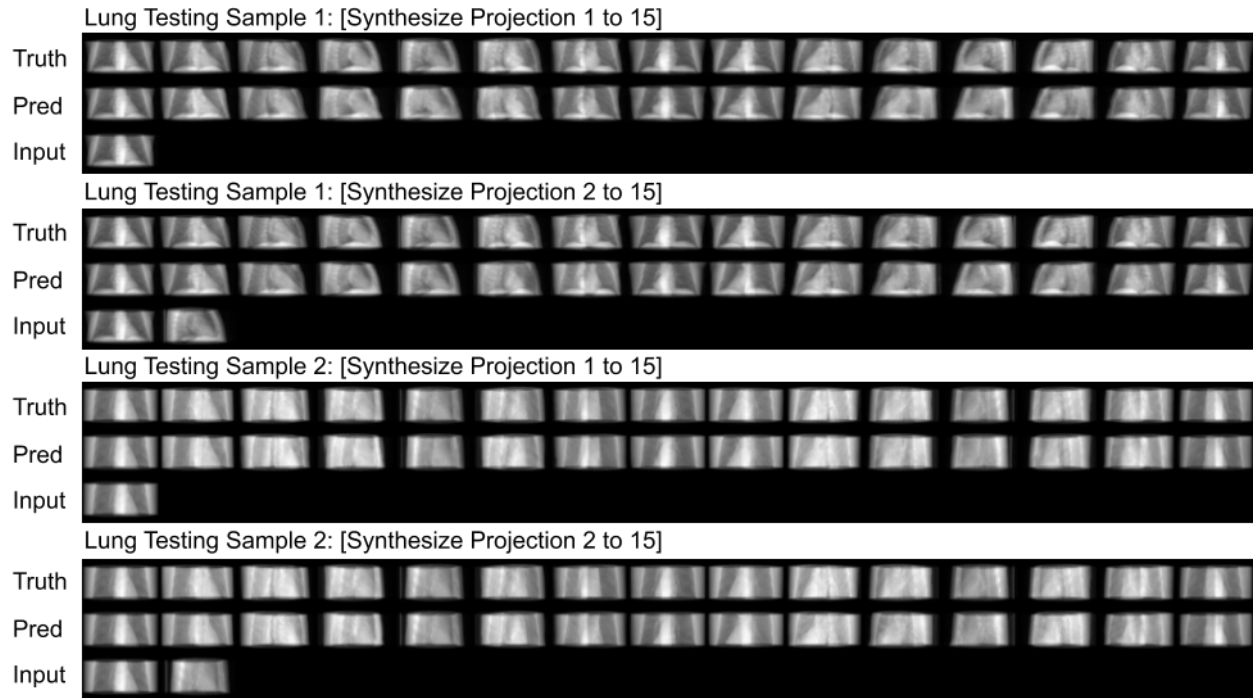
X-ray image generation results of two lung testing samples. Ground-truth and predicted novel-view X-ray images from 15 view angles when 1 or 2 projection(s) are inputted.
